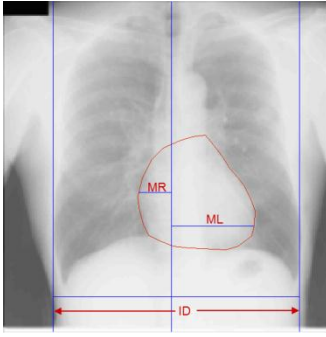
Chest Radiograph with heart outline showing the maximum internal diameter of the thorax (ID) and maximum transverse diameter of the heart that is the sum of maximum right heart width (MR) and maximum left heart width (ML).
